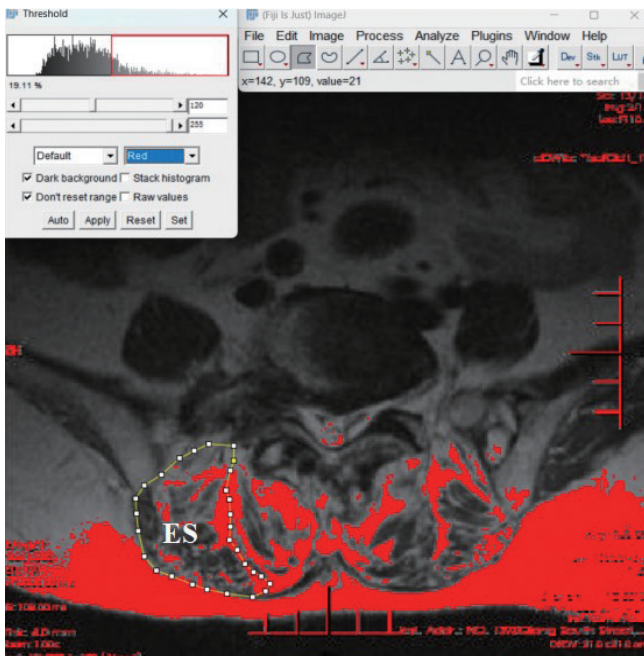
Measurement method of the ES FI. The Image J Threshold method on the middle layer of magnetic resonance image in each segment. Red pixels represent fat tissues. ES, erector spinae; FI, fatty infiltration.
